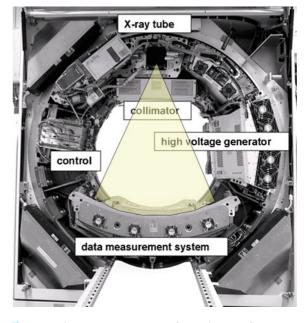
Basic system components of a modern MDCT-system. The X-ray fan beam is indicated in *yellow*, it covers a SFOV of typically 50 cm in diameter. The data measurement system consists of detector and detector electronics
